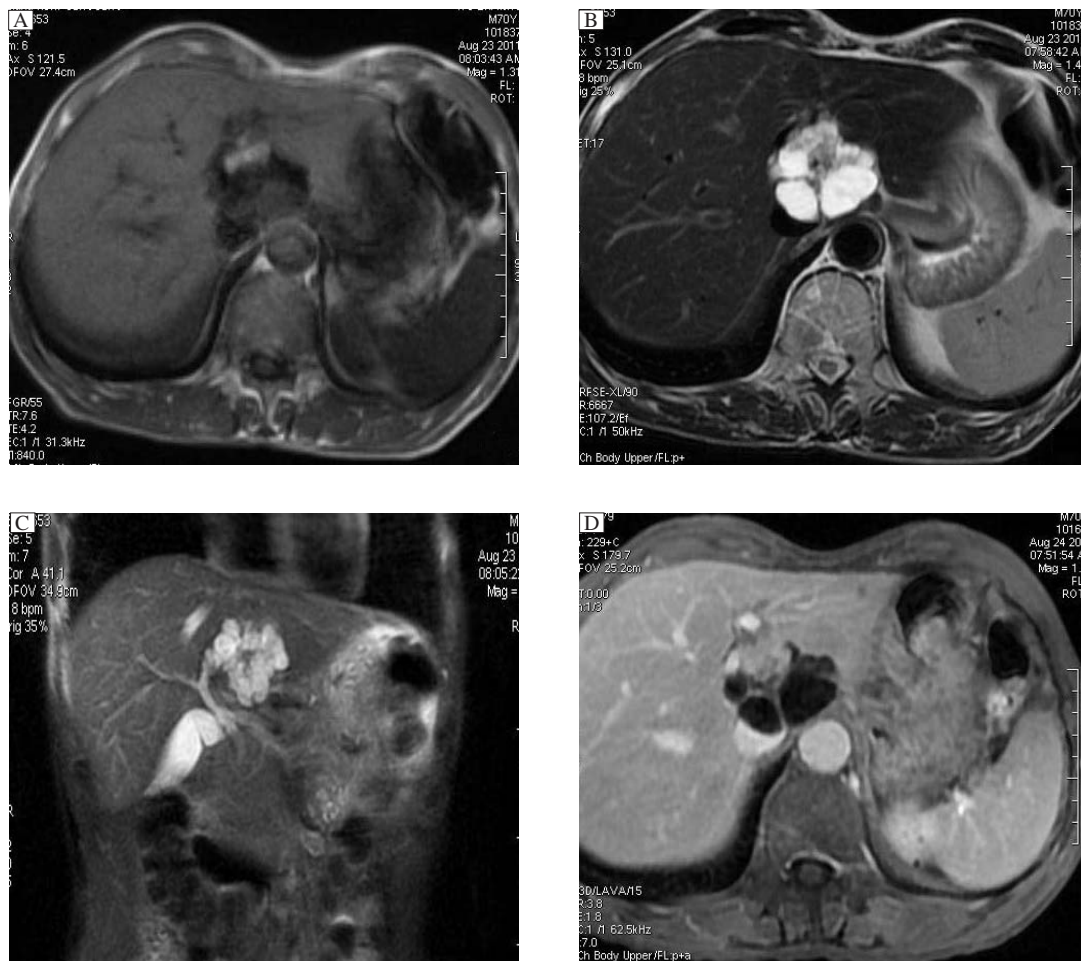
Magnetic resonance imaging of the abdomen. The results show a low intensity area on T1WI (A), and a high intensity area on T2WI (B) as a multilocular cystic lesion with mural nodule, and petal-like high intensity area on 2D-FIESTA(C), and LAVA dynamic contrast-enhanced scan showing enhanced mural nodule and internal septa (D).
